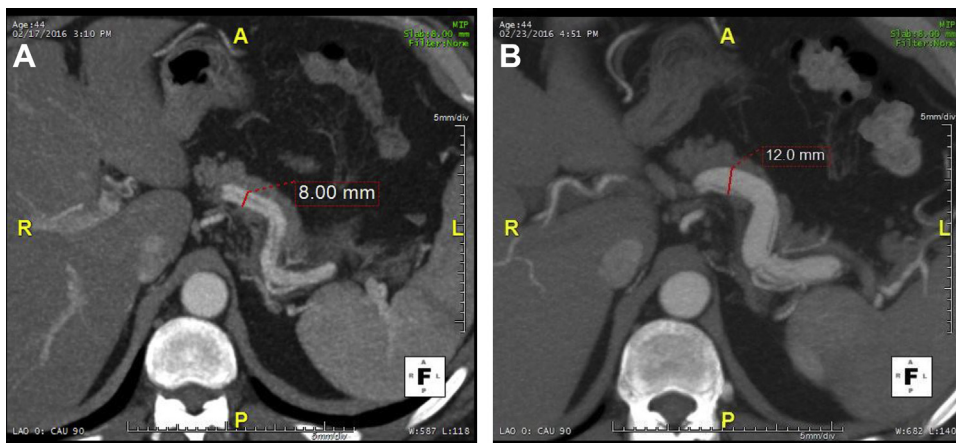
A and B, Comparison axial computed tomography angiography (CTA) images showing splenic artery diffusely dilating over 6 days from 8 to 12 mm.
